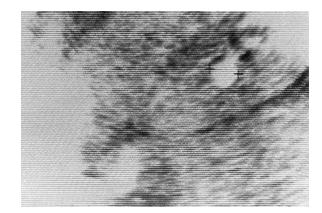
Congenital hepatic fibrosis. Ultrasound of the kidney in a patient with congenital hepatic fibrosis reveals a cystic structure.
